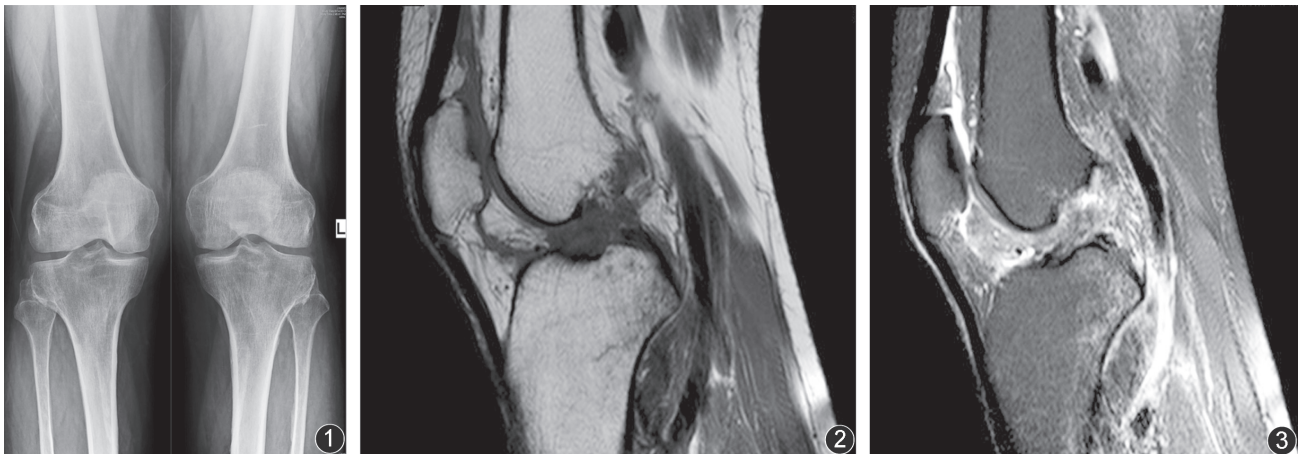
Anteroposterior weight bearing radiograph showing minimal degenerative changes in the knee. Figure 2. MRI image (T₁, sagittal) showing complete ACL tear with minimal effusion and intact articular cartilage. Figure 3. MRI image (T₂, sagittal) showing complete ACL tear with minimal effusion and intact articular cartilage.
